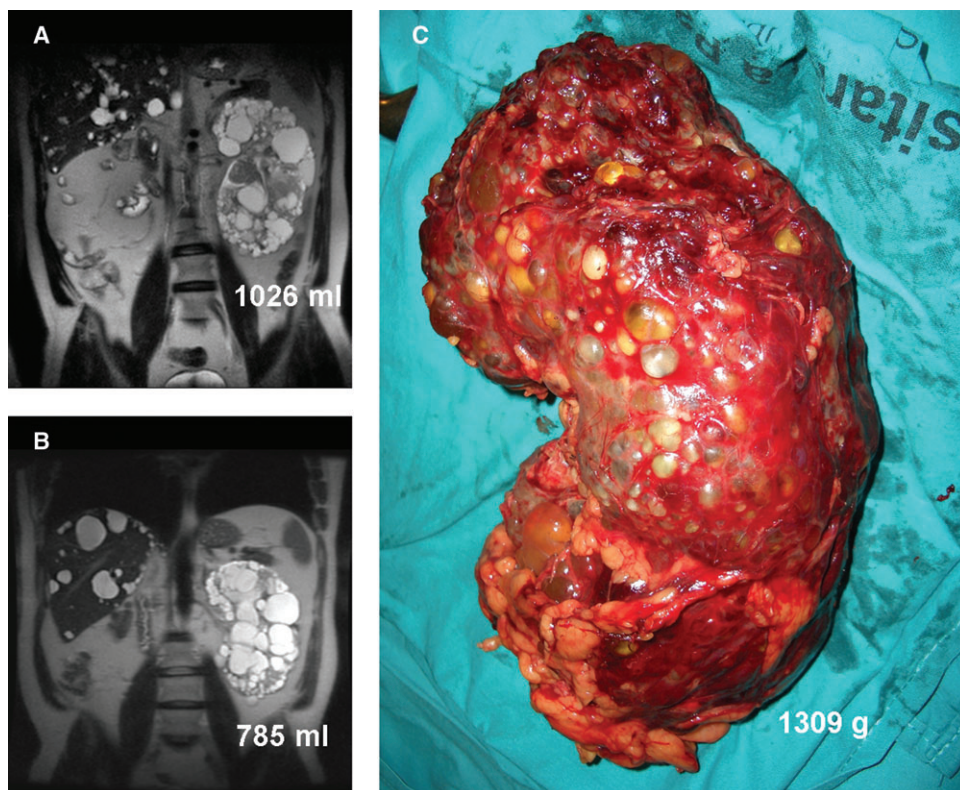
Coronal MRI of a patient with ADPKD, before (A) and after (B) 6-months treatment with low-dose rapamycin. (C) Macroscopic view of the left kidney after nephrectomy.
